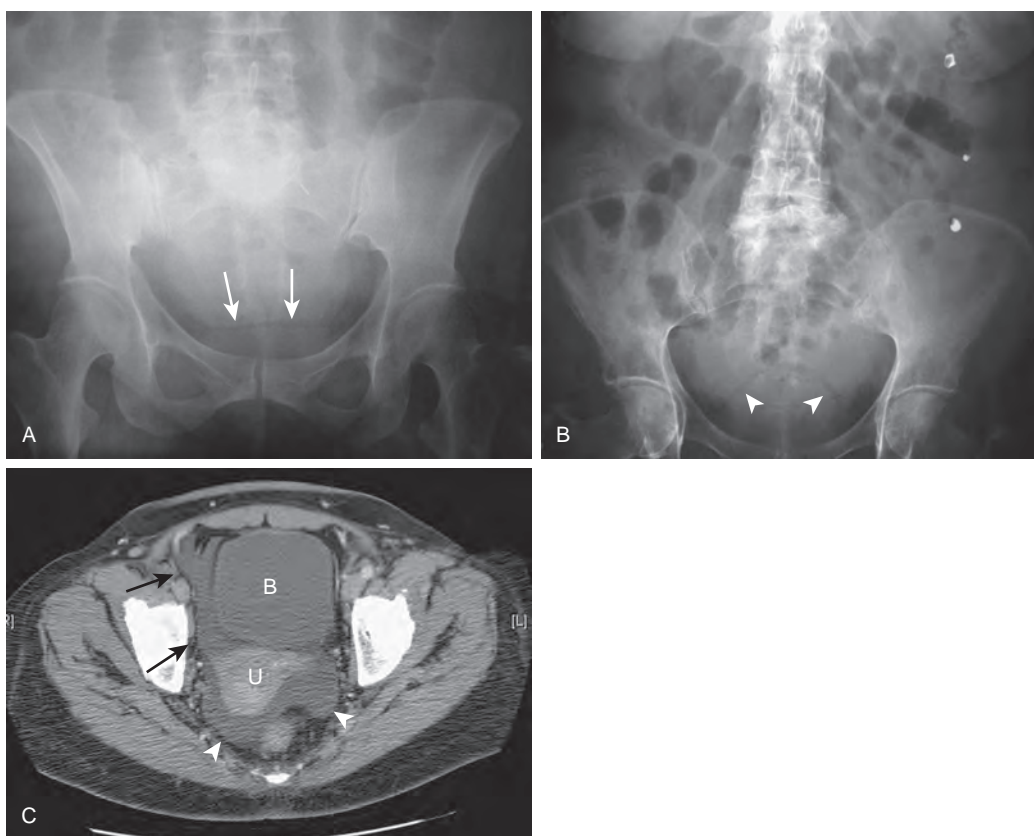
Ascites demarcated by perivesical fat. A. Coned-down view of pelvis from a supine abdominal radiograph shows evidence of ascites with increased density above the perivesical fat (arrows). Also note how the small bowel is displaced medially by ascitic fluid in the abdomen. B. Increased density is again seen in the paravesical spaces above the bladder on a supine abdominal radiograph in another patient with ascites. Note how the top of the bladder is outlined by perivesical fat (arrowheads). C. Axial CT of the pelvis in the same patient as in B confirms the presence of ascites (black arrows) around the bladder (B). Also note fluid (arrowheads) behind the bladder, surrounding the uterus (U).
